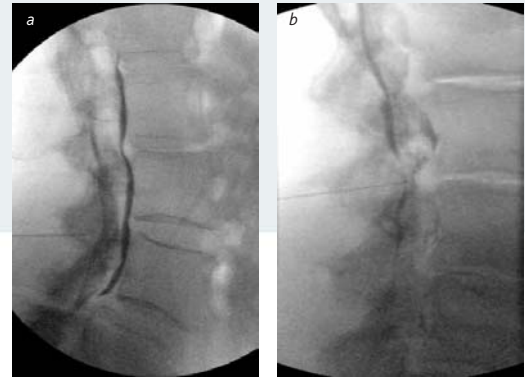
Intralaminar lumbar epidurography performed prior to injection of local anaesthetic and steroid suspension into the epidural space. (a) Lateral radiograph demonstrates widespread dispersal of contrast within the epidural space circumferentially, surrounding the unopacified thecal sac. (b) Lateral epidurogram in another patient revealing severe stenosis at the L2-3 level and moderately severe stenosis at L1-2.
